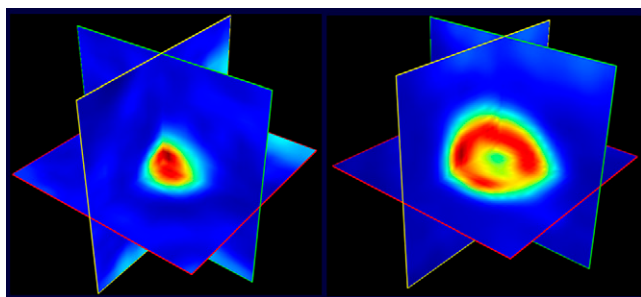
Entropy discriminates between (left) a non-necrotic lesion (entropy = 2.03; SUV_{max} = 4.3; volume = 6.1 mL) and (right) a necrotic lesion (entropy = 2.9; SUV_{max} = 10.1; volume = 50 mL).
